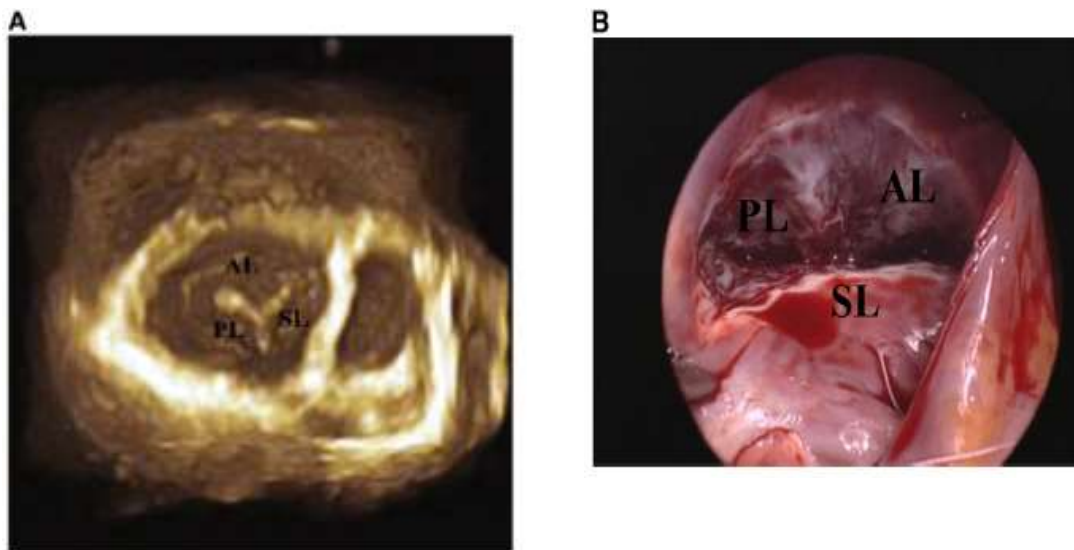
3 dimensional transthoracic echocardiography (a) and intraoperative echocardiographic view (b) of the tricuspid valve. SL = septal leaflet, AL = anterior leaflet, and PL posterior leaflet. Image from ^[23]
